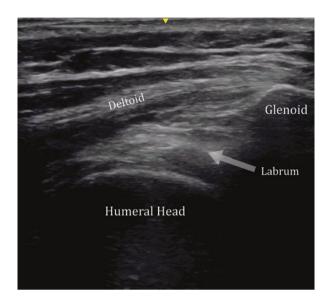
Ultrasound image of the glenoid fossa and labrum
